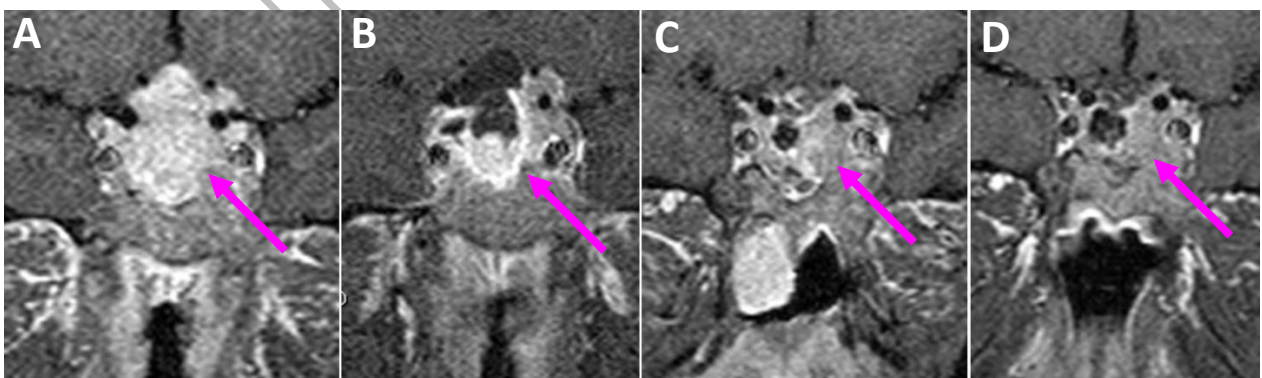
T1 weighted magnetic resonance Imaging of sella
